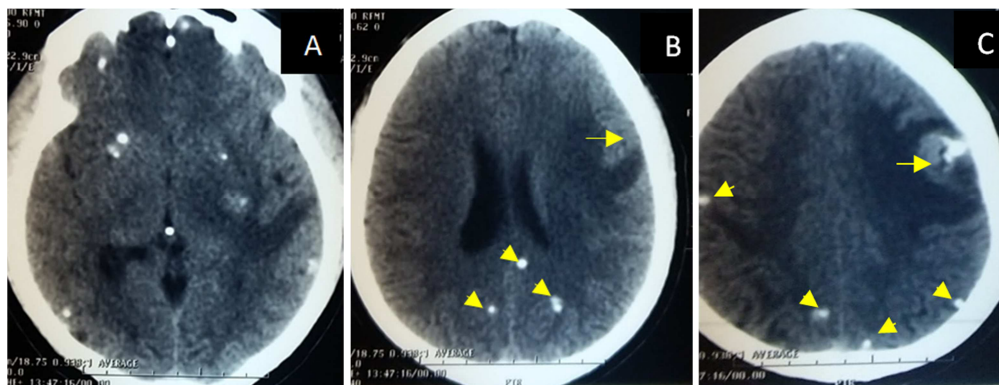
Non-Contrast axial Head CT Scans Showing in (A): Multiple Brain Benign-Appearing Calcifications Without Associated Mass Effect both Cerebral Hemispheres; in (B): 3 Spontaneous Calcifications in both Occipital lobes and a left Frontal Hypodensity Which in (C): is Enhanced by Contrast Product.
